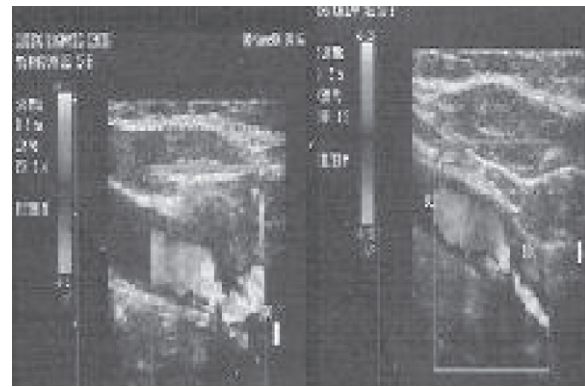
a,b: Doppler right (a) and left (b) suggestive of 90% block of bilateral internal carotid artery
